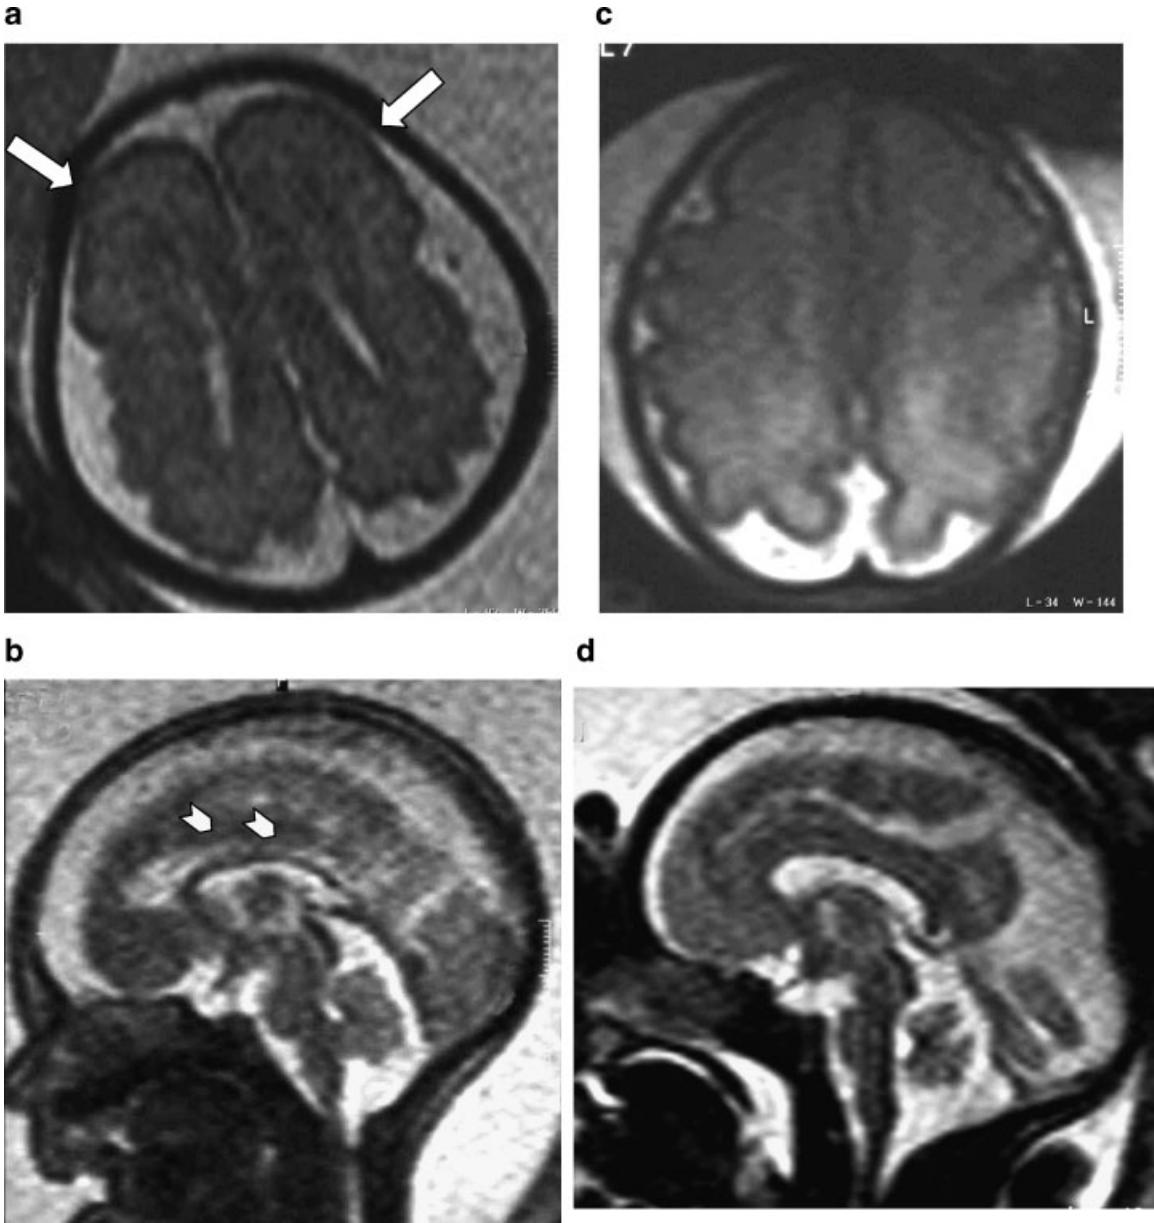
MRI images of the patient's brain showing poorly defined sulci in the frontoparietal region, bilaterally (arrows) (a), and the corpus callosum lacking genu et splenium (arrowheads) (b). Comparison with brain MRI from a healthy 29 weeks-old fetus (c, d).
